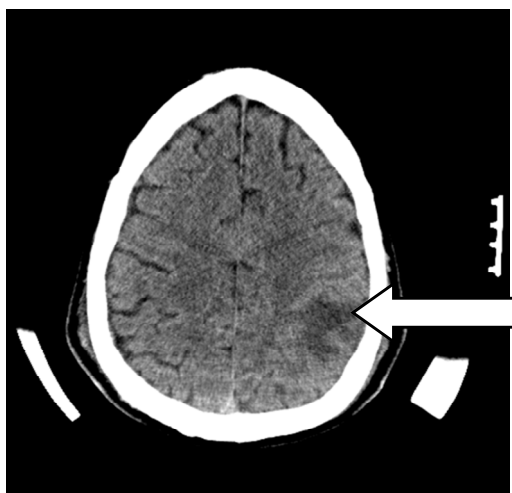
CT brain without contrast. Ill defined area of hypodensity in left parietal lobe with vasogenic edema incompletely visualized due to halo device.
